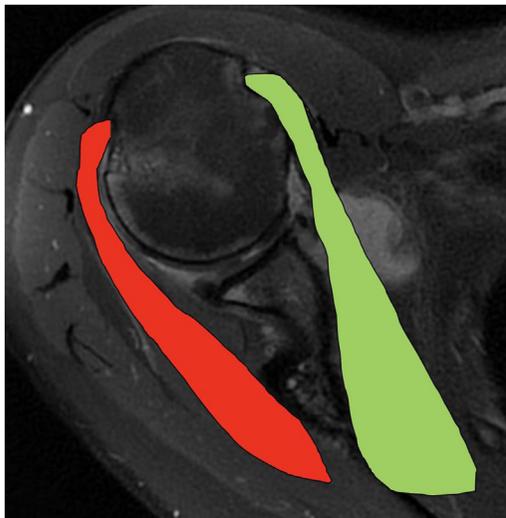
Axial proton dense fat saturation image on an MRI that demonstrates the subscapularis (green) and the infraspinatus (red), which act as a force couple to balance the shoulder.
